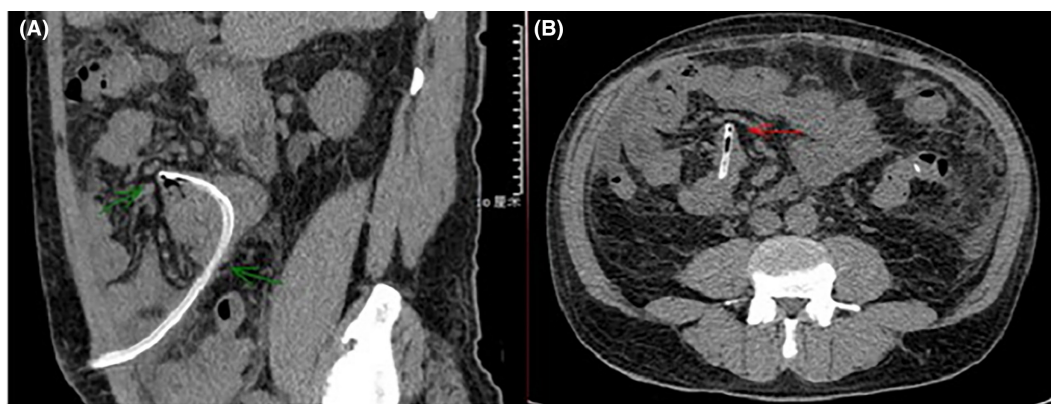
Abdominal computed tomography showed a catheter penetrating the small intestine during the first peritonitis hospitalization. (A) Sagittal section: The catheter enters the small intestine (arrow). (B) Coronal section: The catheter passes through the intestinal wall (arrow).
